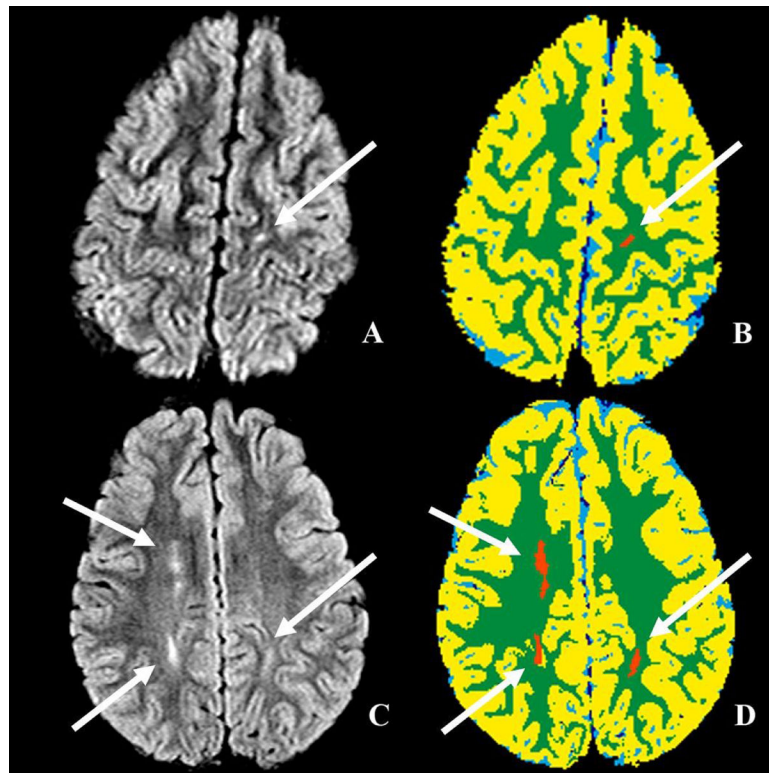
Examples of silent infarct and leukoencephalopathy. A, B axial fluid attenuation inversion recovery (FLAIR) sequences; C, D corresponding segmented maps (arrows).
